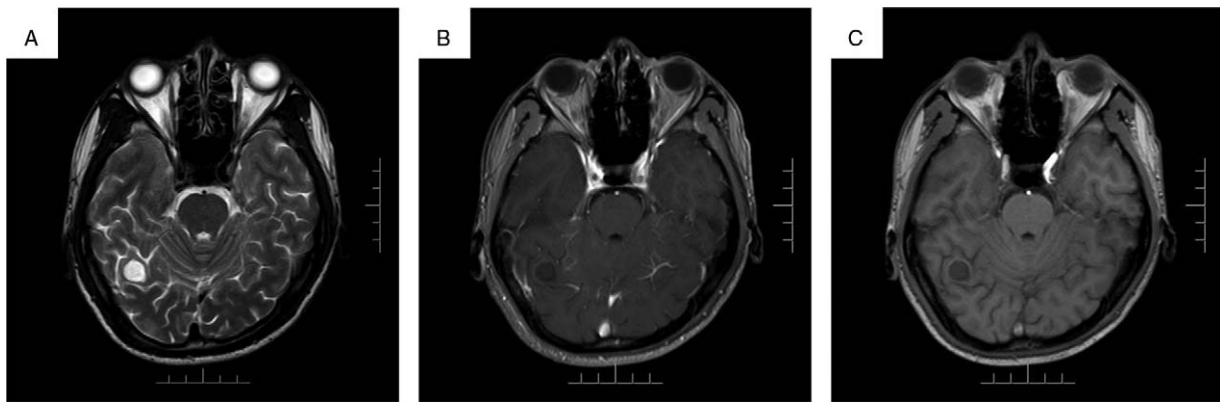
Neuroradiologic features of DNT-like PA. (A) Axial T2-weighted MRI showed a $1.1 \times 1 \times 1$ cm round homogenous hyperintense mass in right temporal-occipital lobe. (B) Axial T1-weighted MRI showed slightly hypointense mass. (C) Contrast-enhanced T1-weighted MRI showed no enhancement of the mass. DNT=dysembryoplastic neuroepithelial tumor, PA=pilocytic astrocytoma.
